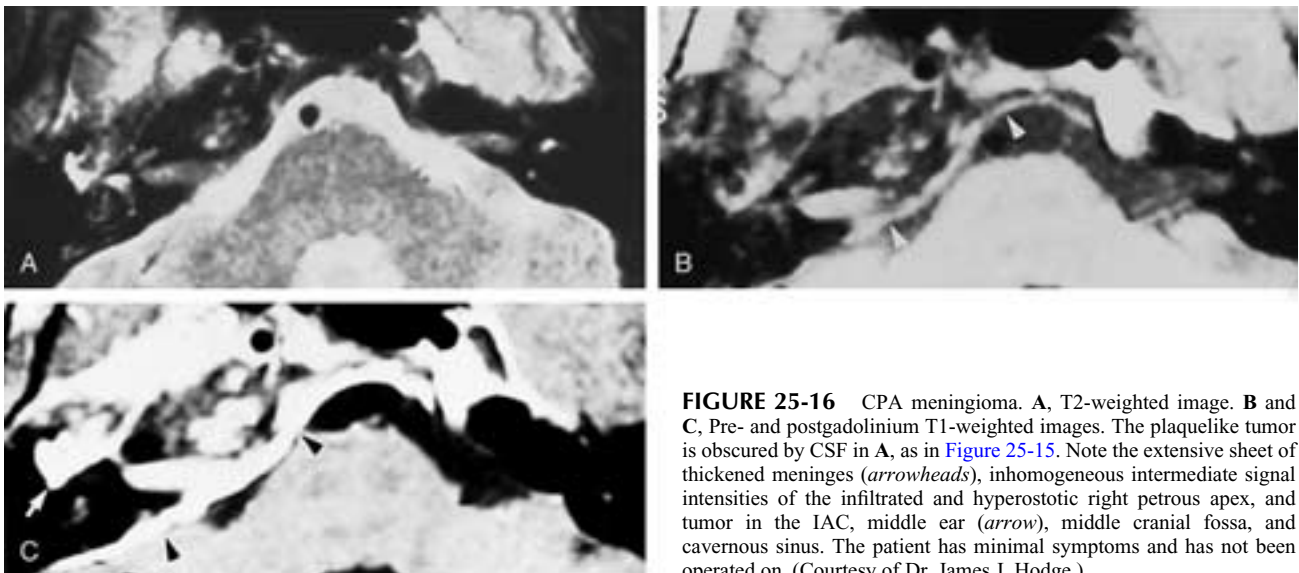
CPA meningioma. A, T2-weighted image. B and C, Pre- and postgadolinium T1-weighted images. The plaque-like tumor is obscured by CSF in A, as in [Figure 25-15](#). Note the extensive sheet of thickened meninges (*arrowheads*), inhomogeneous intermediate signal intensities of the infiltrated and hyperostotic right petrous apex, and tumor in the IAC, middle ear (*arrow*), middle cranial fossa, and cavernous sinus. The patient has minimal symptoms and has not been operated on. (Courtesy of Dr. James J. Hodge.)
